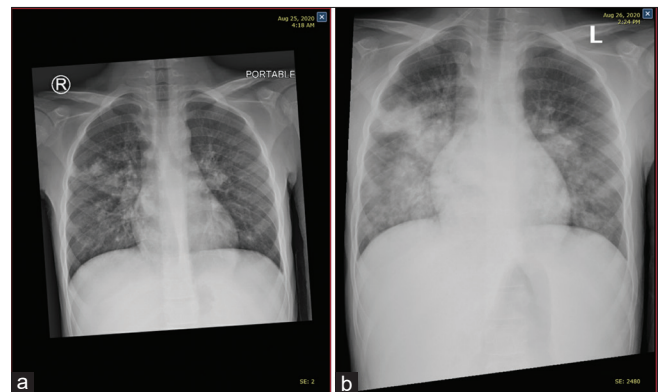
Chest Xray showed radiological progression of case 1
